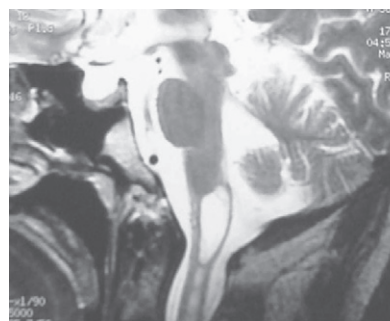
MRI (T2-weighted sagittal image) showing bulbar extension of the syrinx
